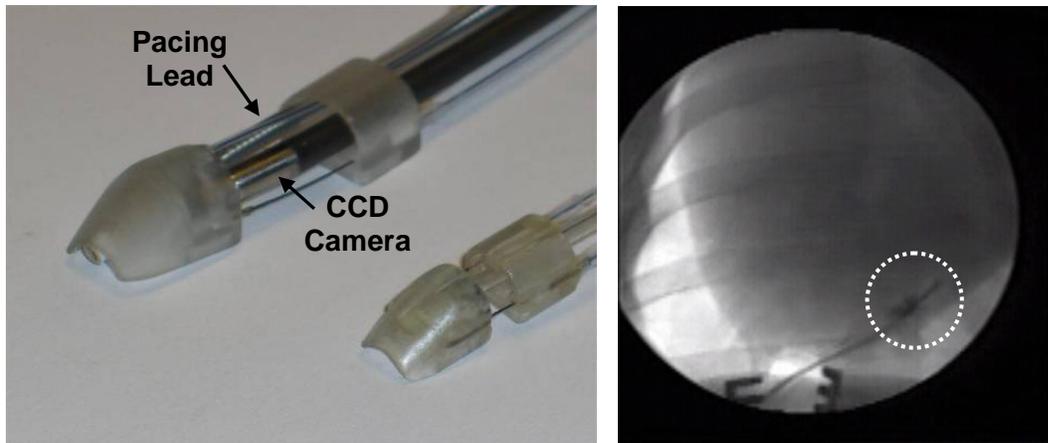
(left) The third HeartLander prototype, and an enlarged version to carry the CCD camera and remote epicardial lead placement system. (right) Verification of the location and successful attachment of the epicardial lead on the poster wall of the left ventricle using fluoroscopy (x-ray video). HeartLander highlighted by circle.
